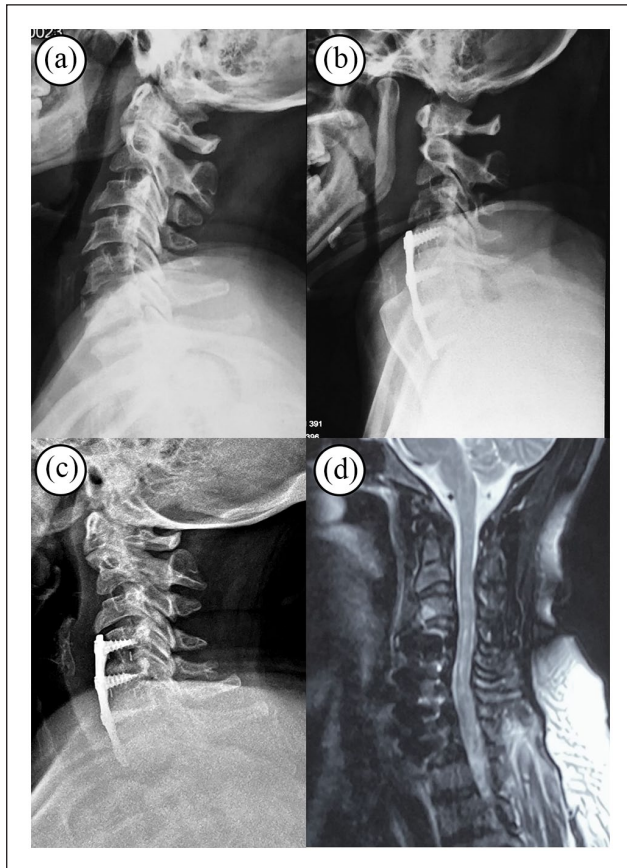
(a) Preoperative cervical X-ray image. (b) Postoperative cervical X-ray image (3 days after operation). (c) Cervical X-ray 6 months after the operation. (d) T2-weighted sagittal MRI image six months after the operation.
